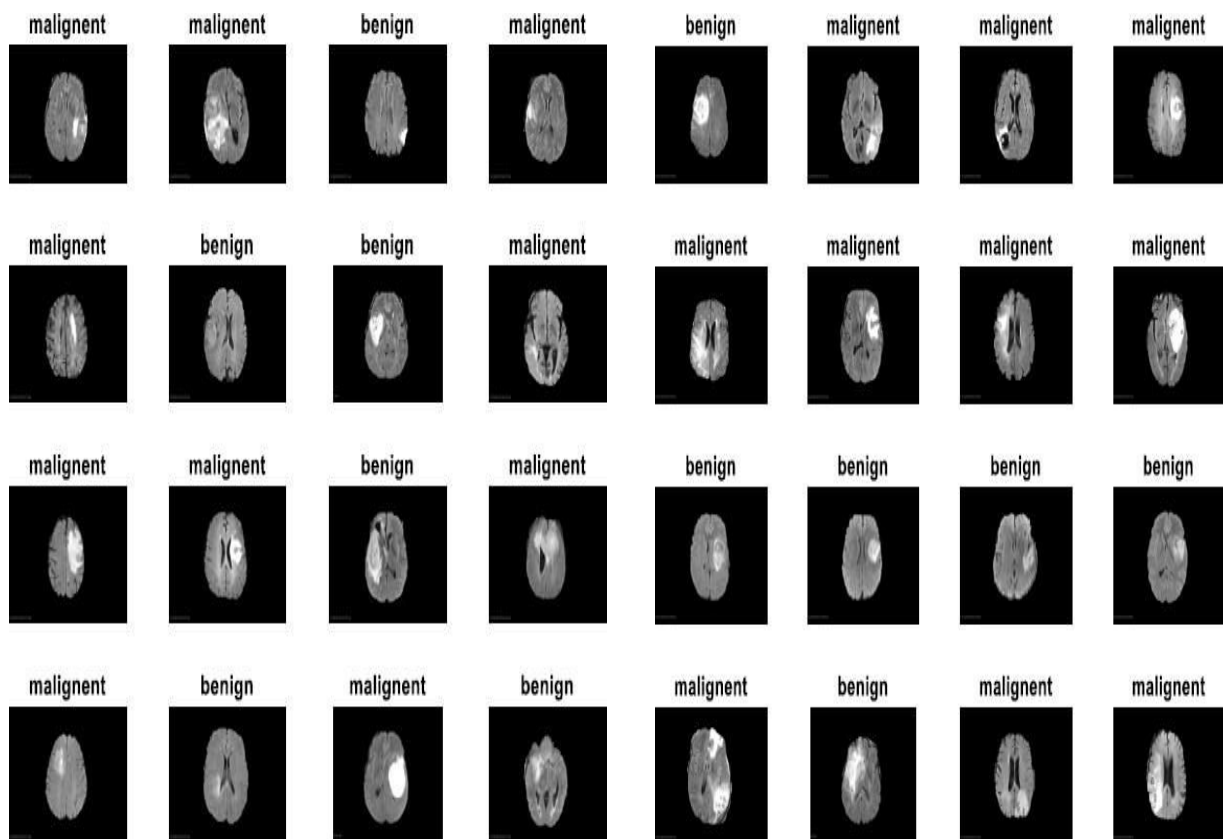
All the predicted types of Brain Tumours detected based on the Trained Dataset of MRI Images.
